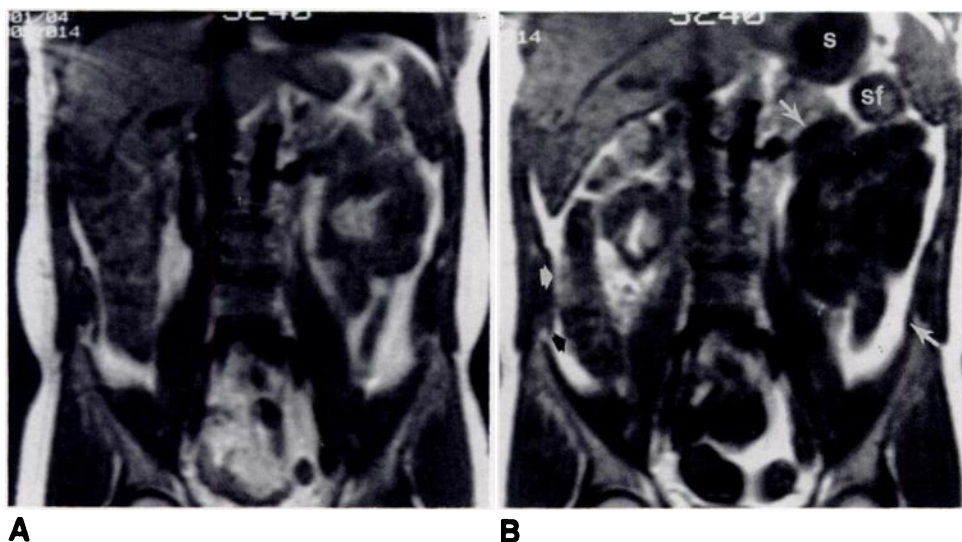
Coronal T1-weighted MR images of abdomen.
